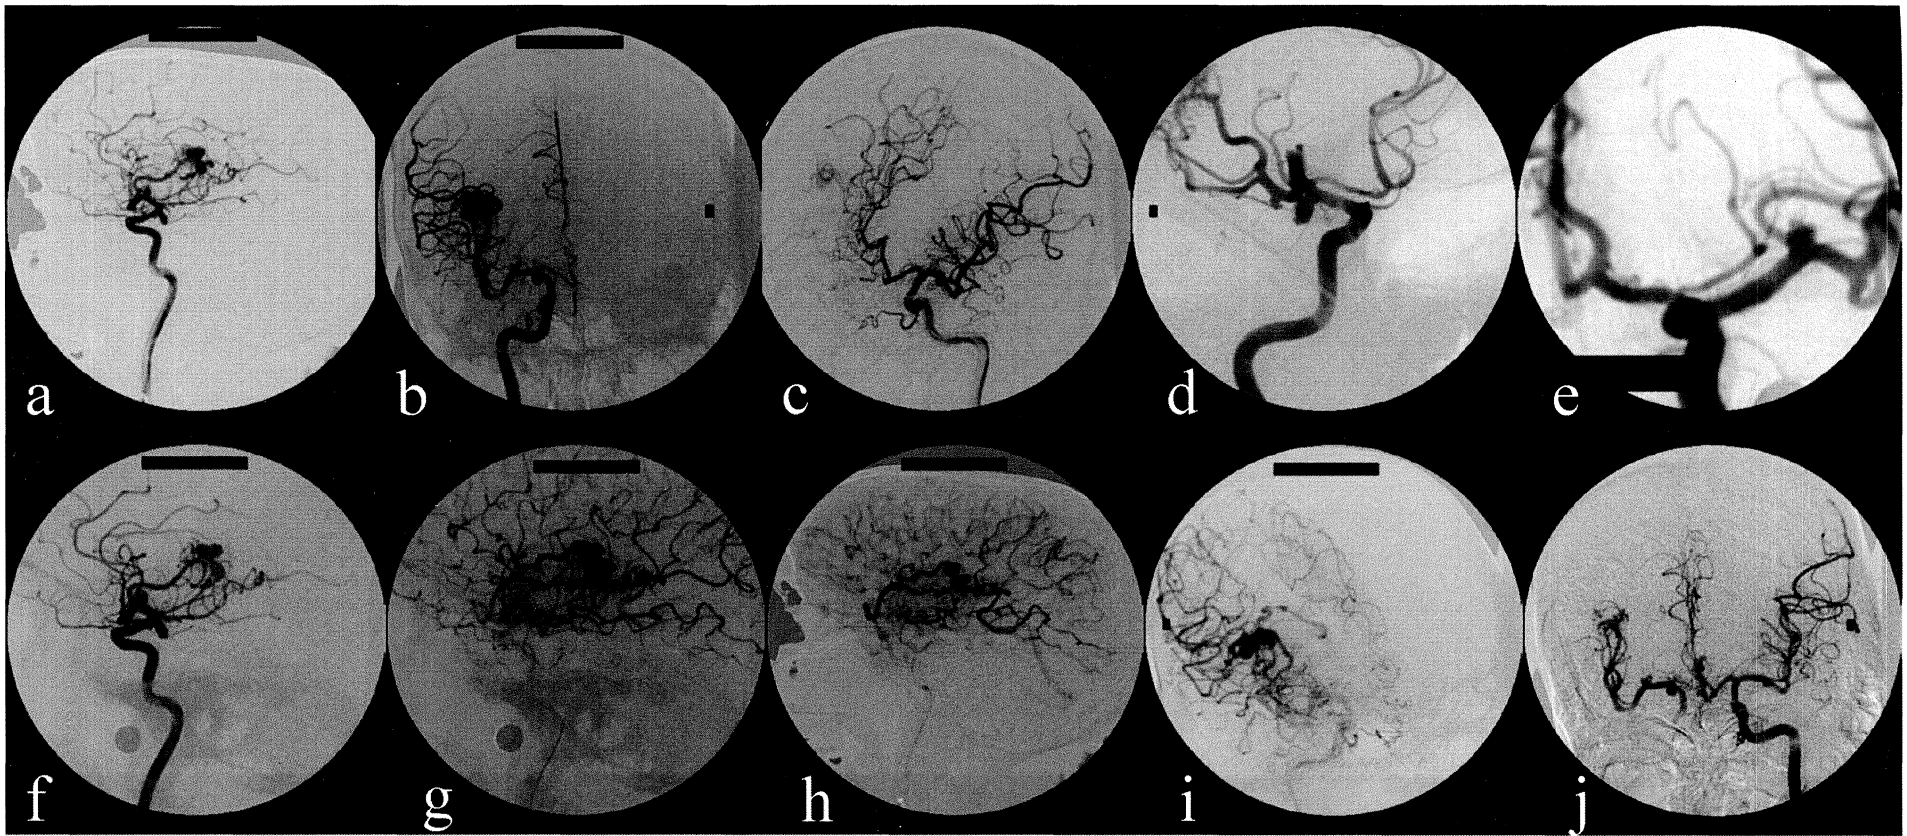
53 year old gentleman, presented with h/o holocranial headache lasting for 12 hours. CT showed IVH. DSA (a – j) revealed a right insular AVM, with multiple unruptured intracranial aneurysm- 1. distal M1 segment of MCA projecting super-laterally (a,b), 2. Right ParaPcom aneurysm measuring 6.4x4.3 mm, projecting postero-superiorly (a, b, d), 3. Lt MCA bifurcation measuring 3.7x 3.6 mm, projecting antero-superiorly (e). The AVM was fed from right MCA, mid post frontal branch and callosomarginal branch of right ACA, with venous ectasia and deep vein drainage into Basal vein of Rosenthal and ICV (f-i).
